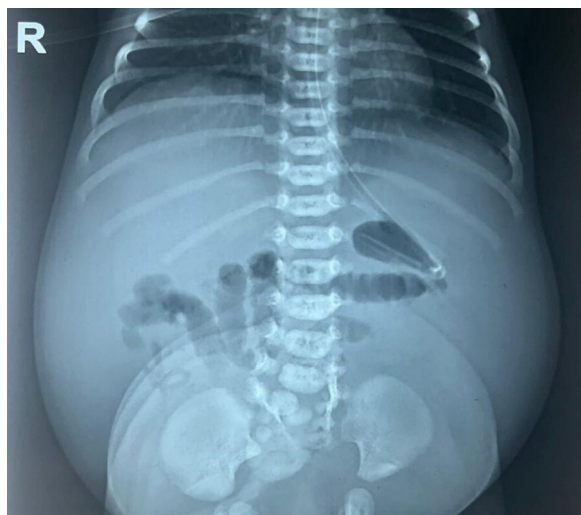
Abdominal X-ray: ascitis with distended bladder and sacral vertebral anomalies.
